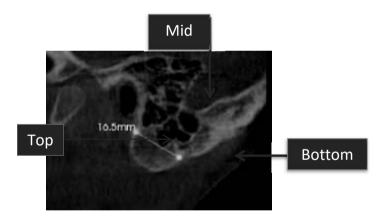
Radiographic density
